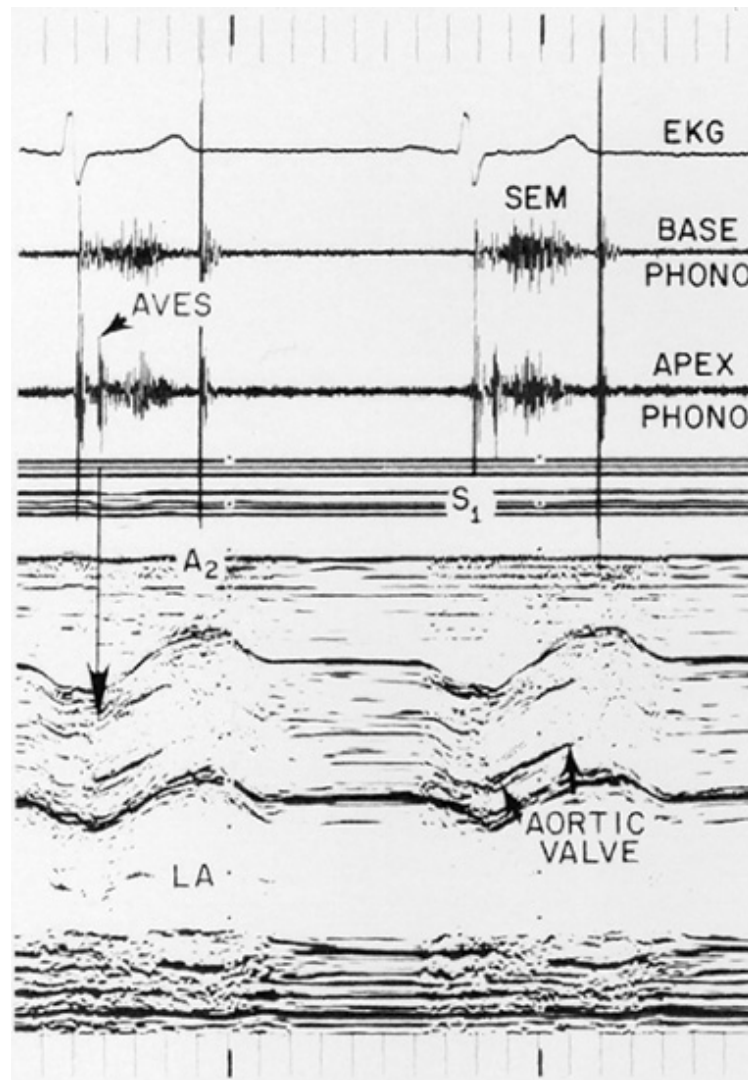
Base and apex phonocardiograms are recorded simultaneously with the aortic valve echocardiogram in a young man with valvular aortic stenosis. A prominent aortic valvular ejection sound (AVES) is recorded at the apex and is coincident with the maximal excursion of the aortic valve in early systole. It is followed by a crescendo-decrescendo systolic ejection murmur (SEM) that ends well before a loud A_2 .
